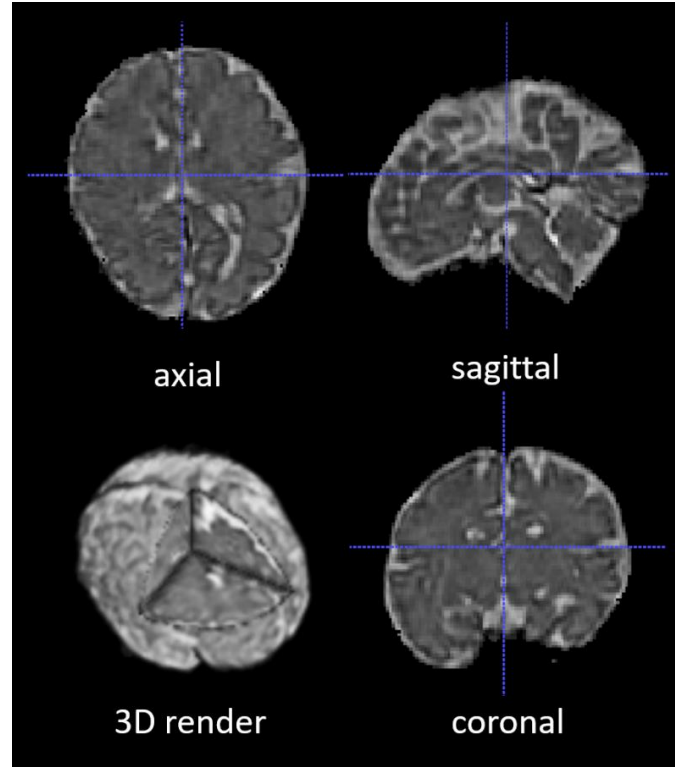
Segmented and volumetrically reconstructed fetal brain image using NiftyMIC. The original 2D slices of fetal MR images were automatically segmented and manually adjusted for fetal brain 2D masks. Then the 2D slices and 2D brain masks were reconstructed into 3D volumes and 3D masks with motion correction. This figure shows an example of the skull-stripped, orientation-adjusted 3D fetal brain volumes in axial, sagittal, coronal, and 3D rendered views.
